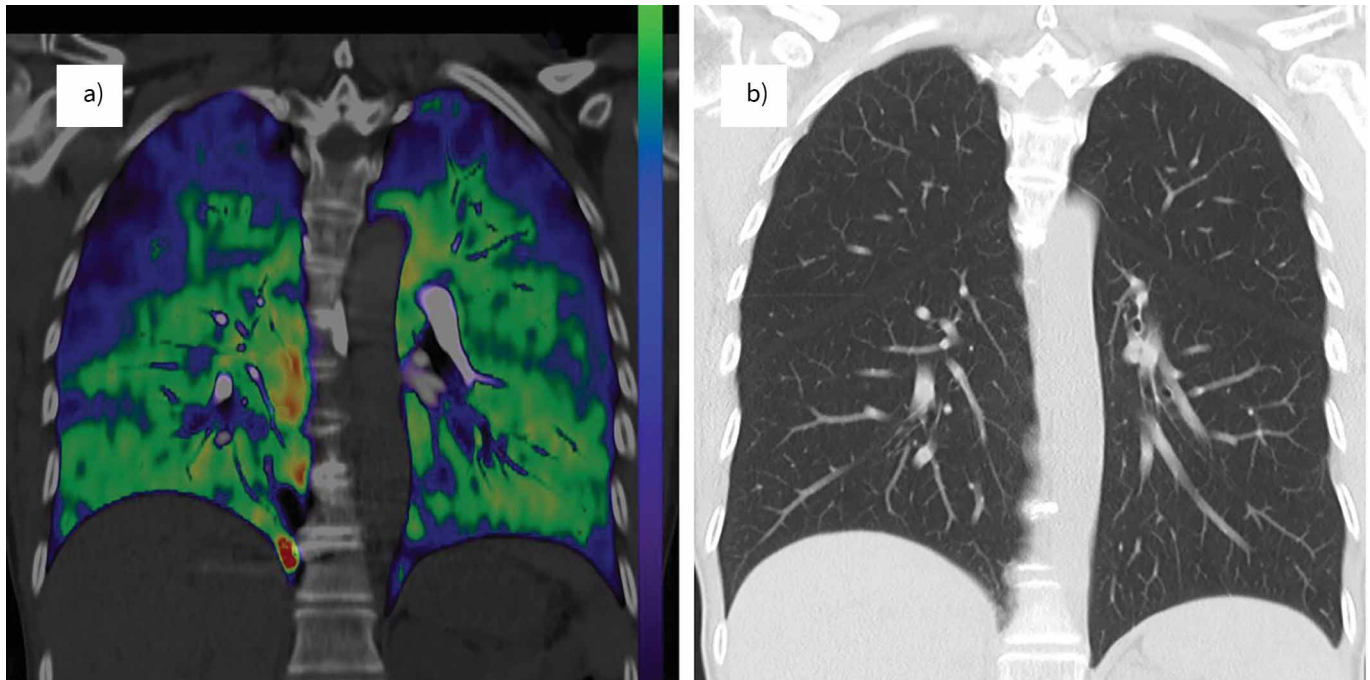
a) Coronal dual-energy computed tomography perfused blood volume iodine map with computed tomography overlay in a 59-year-old female with dyspnoea, fatigue and chest pain imaged 11 months after onset of mild coronavirus disease 2019 pneumonia. Diffusing capacity of the lung for carbon monoxide was 72% predicted with otherwise normal spirometry. Upper-lobe subpleural iodine distribution defects (represented as blue and black overlay, approximating <40 HU) in the subpleural apices bilaterally correspond with similar unmatched defects on perfusion scintigraphy. Computed tomography angiography did not demonstrate pulmonary arterial thrombus. b) Corresponding coronal computed tomography image shows normal lung parenchyma.
